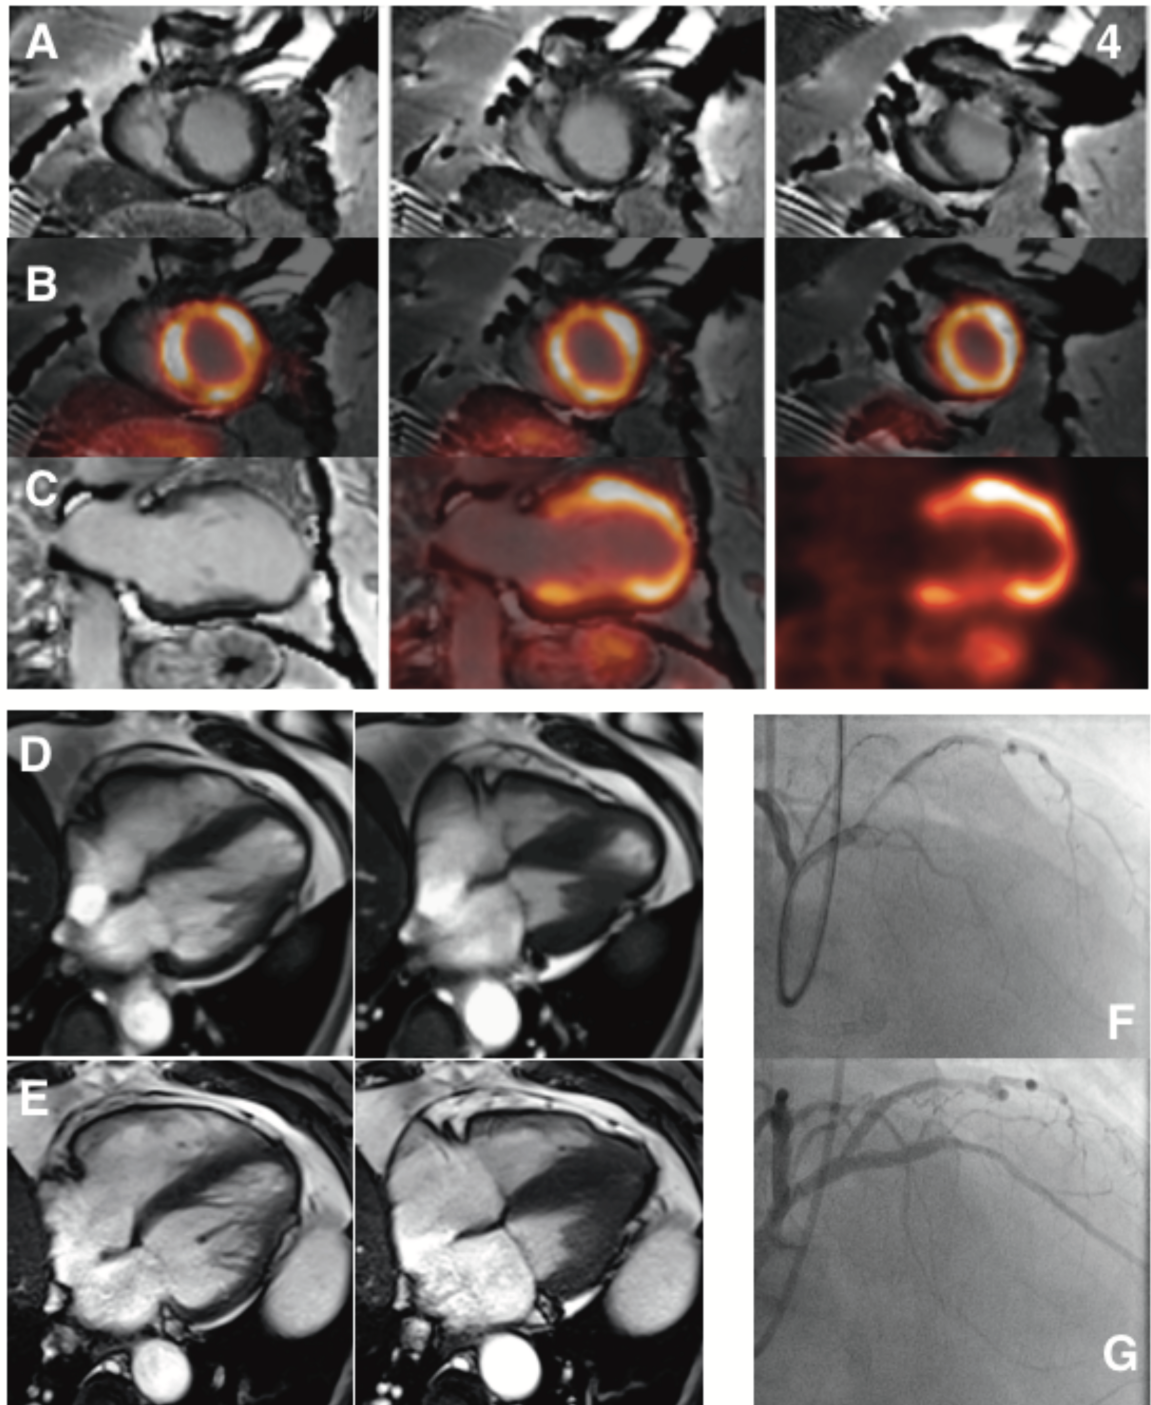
Example of a patient with a CTO of the LAD. In A, MRI short axis slices show a thinned anteroseptal left ventricular wall with non-transmural LGE. PET/MR fused short axis acquisition are presented in B, showing an overall PET-viable myocardium. C shows a 2-chamber view of fused PET/MR acquisition. Enddiastolic (left) and endsystolic (right) cine sequences in 4-chamber view at baseline (D) and at follow-up (E) show an improvement of the hypokinesia of the apex. Coronary angiography of the CTO of the LAD before (F) and after successful revascularization (G).
